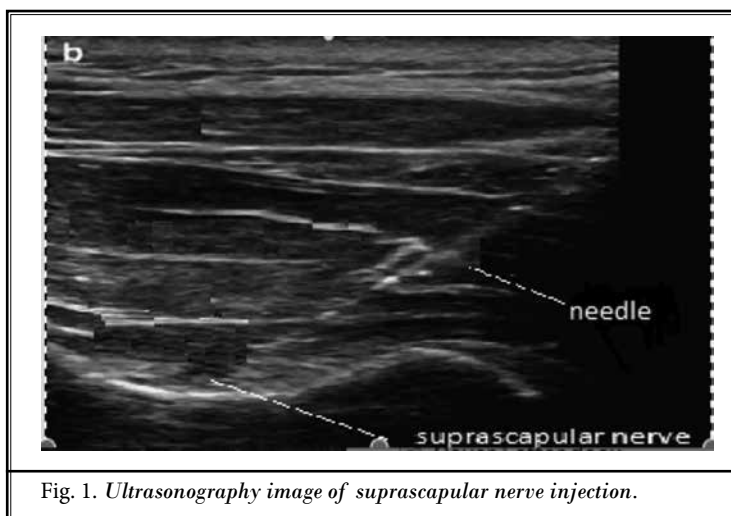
Ultrasonography image of suprascapular nerve injection.
